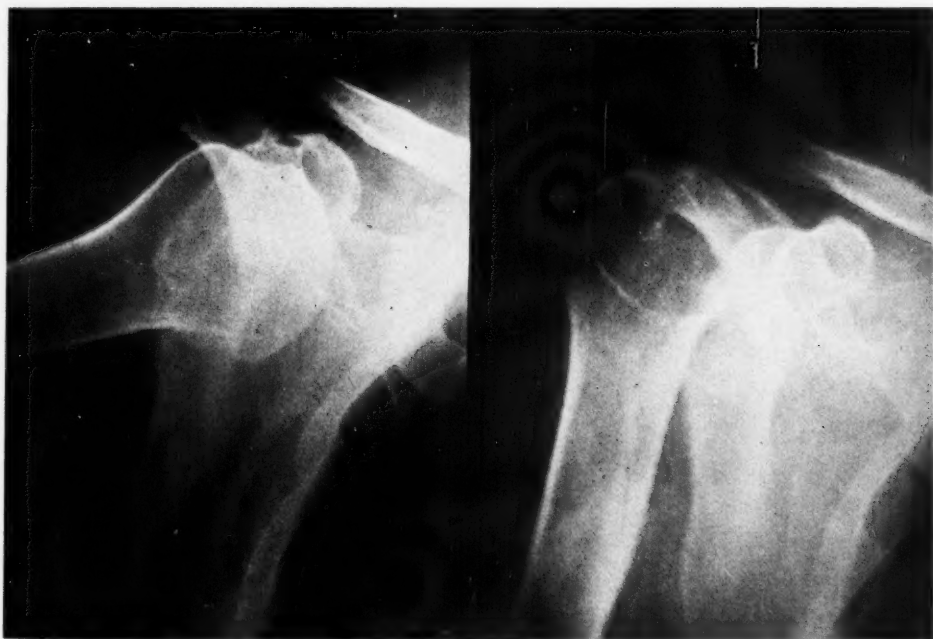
Case 3. C. K., No. 94,788, male, 71 years of age, came to the Emergency Division on Oct. 14, 1934. He had slipped on the top step of a stairway and had fallen down fourteen steps, hitting on his right shoulder. There was a subcoracoid dislocation with fracture of the inner third of the clavicle. This was confirmed by roentgen ray. After reduction there was observed the appearance of a cyst-like shadow at the upper end of the humerus.
